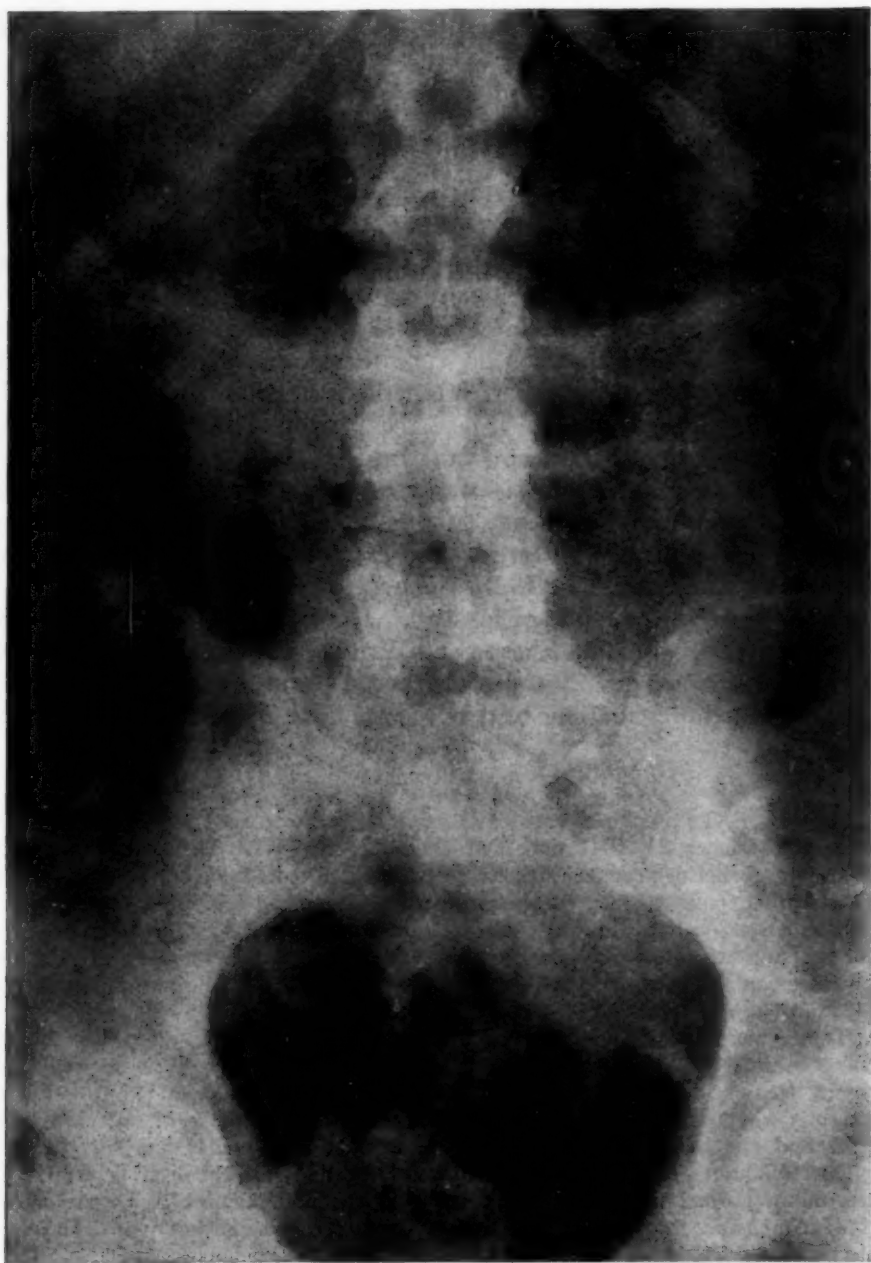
(*Case 1.*) Roentgenogram of the abdomen showing marked gaseous distention of the stomach.
